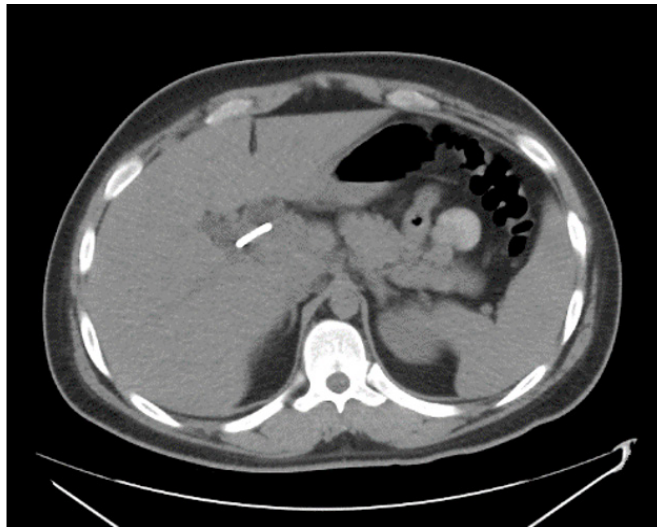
Computed tomography impression: Stent seen in the dilated common hepatic and common bile ducts to the duodenum. The common bile duct (CBD) is normal size. Common hepatic duct and intrahepatic biliary duct are dilated. Pancreatic duct is not dilated.
